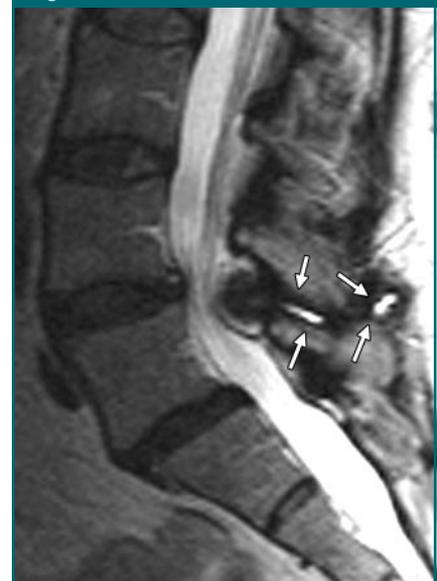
Severe degenerated posterior ligaments. Sagittal midline T2-weighted SE (4000/120) image shows mild grade I degenerative spondylolisthesis at L4-5. There is close approximation of spinous processes of L4 and L5 and high-signal-intensity degenerative changes in the region of intraspinal ligaments (arrows) (Bastrop disease).
